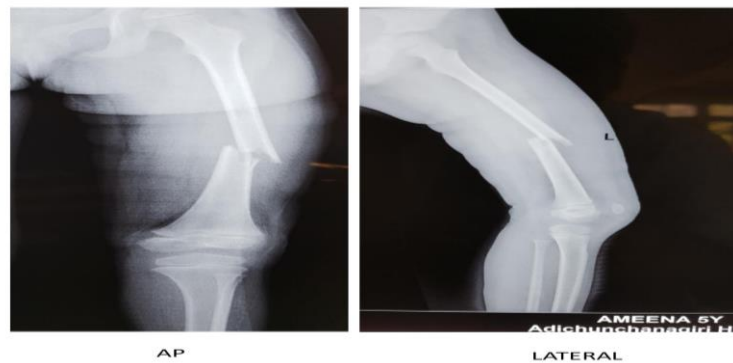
Case 2 - Pre-operative anteroposterior and lateral radiographs showing a displaced mid-diaphyseal fracture of the left femur.
